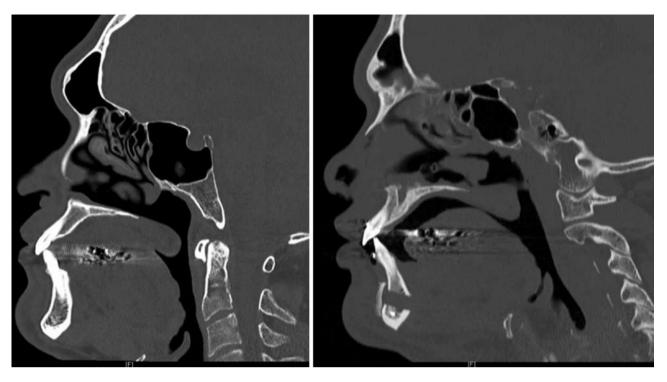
CT scan before and after MMA + GTA surgery showing improper tongue resting positioning. There is now more room for the tongue with the enlarged facial skeleton framework, but the tongue relapses to the preoperative position with a propensity for
